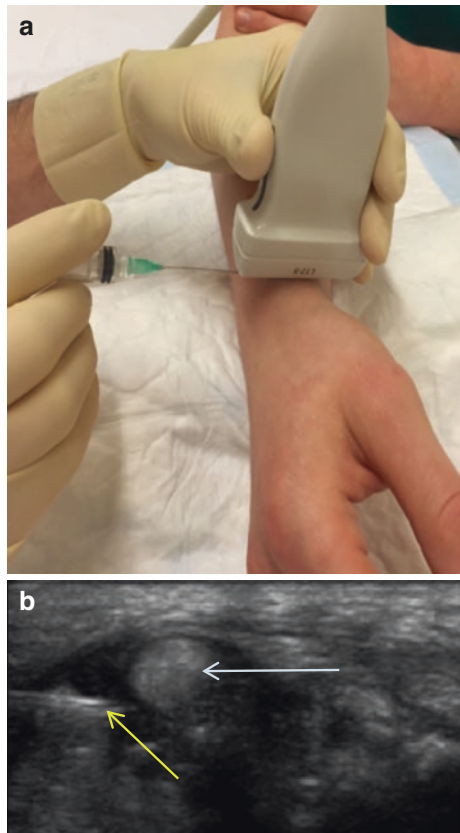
(a) Ultrasound-guided injection EPB, APL in axial plane, from dorsal to ventral. (b) Ultrasound image of injection in axial plane, with the needle (yellow arrow) deep of the tendon (blue arrow)
